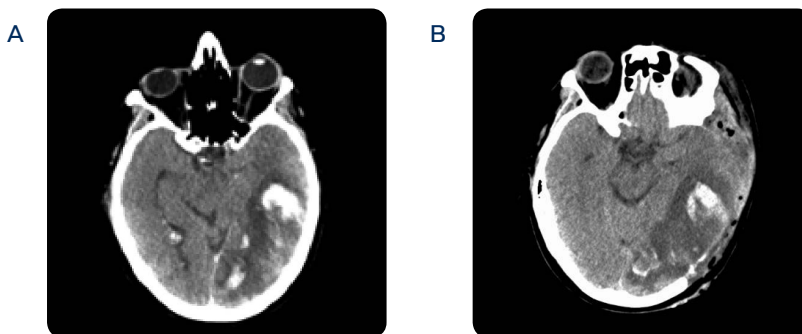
A: Admission CT scan (of patient 4) shows left temporo-parieto-occipital hemorrhagic infarct. B: Direct post-operative CT scan, large decompression extending toward the temporal skull base.
